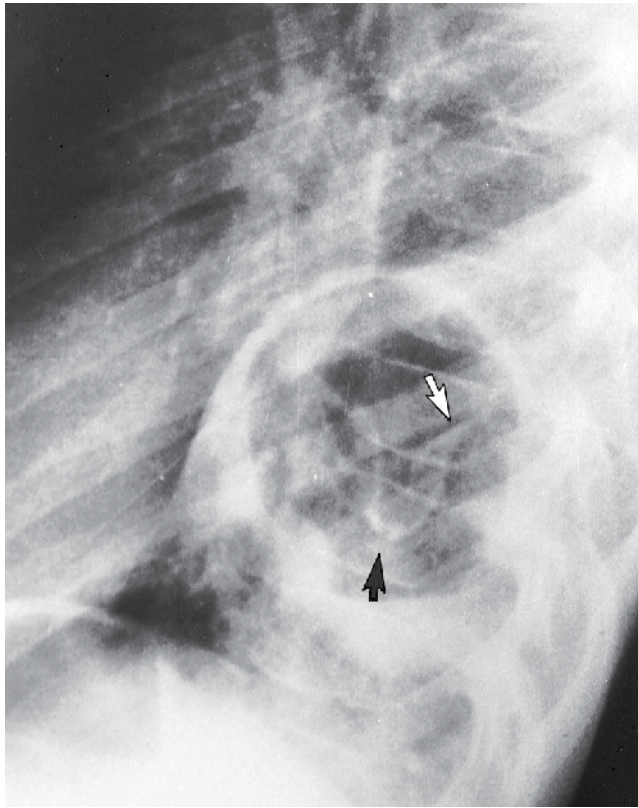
Lung involvement in a child with previous episodes of cough and expectoration. Collimated lateral chest radiograph shows an intracystic serpentine structure representing collapsed membranes (serpent sign) (arrows).
